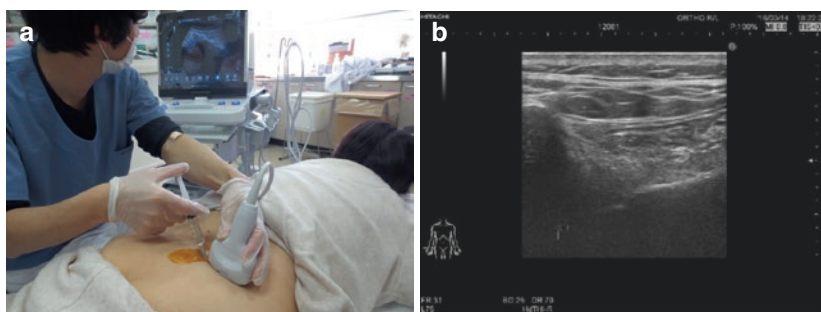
Ultrasound-guided injection method. (a) Injection using an ultrasonic device. (b) The gap between the inner edge of the PSIS and the sacrum can be confirmed
